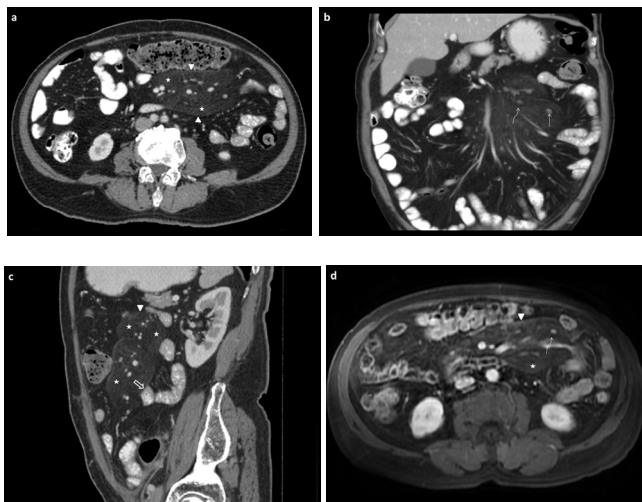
A 71-year old male patient with prostate and colon cancer. a-c. Typical CT findings of mesenteric panniculitis on axial (a), coronal (b), and sagittal (c) views. A pseudomass appearance that slightly displaces but does not invade the neighbouring structures (thick arrow); a pseudocapsule (arrowhead) in the form of a dense line that separates the high attenuated mesenteric fat (asterisk) and normal mesentery; short axis <10mm lymph nodes (thin arrow) in the pseudomass, and hypodense halo (curved arrow) around the vessels and lymph nodes. d. Contrast-enhanced axial MR imaging appearance of mesenteric panniculitis.
